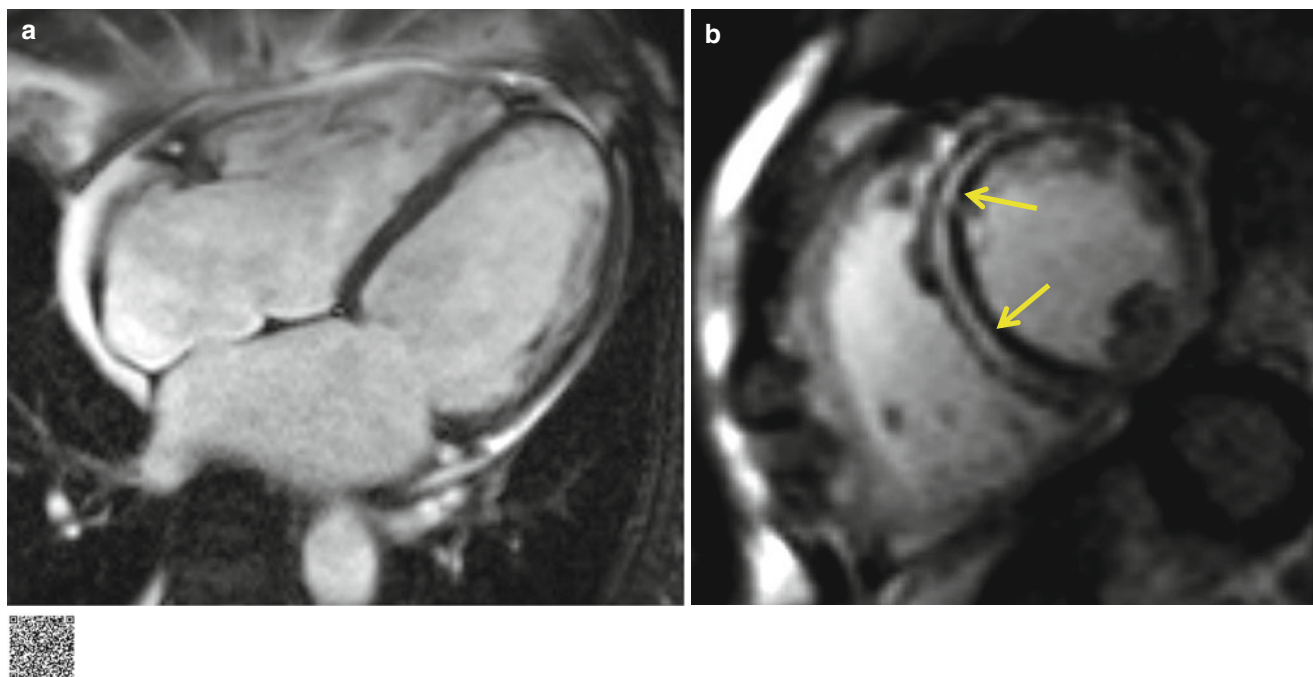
MRI of a patient with idiopathic dilated cardiomyopathy (DCM) (<http://extras.springer.com/2015/978-3-642-36396-2>). (a) Four-chamber cine MRI shows dilated ventricles. Calculated left ventricular ejection fraction using cine MRI was 39 %. (b) Delayed
